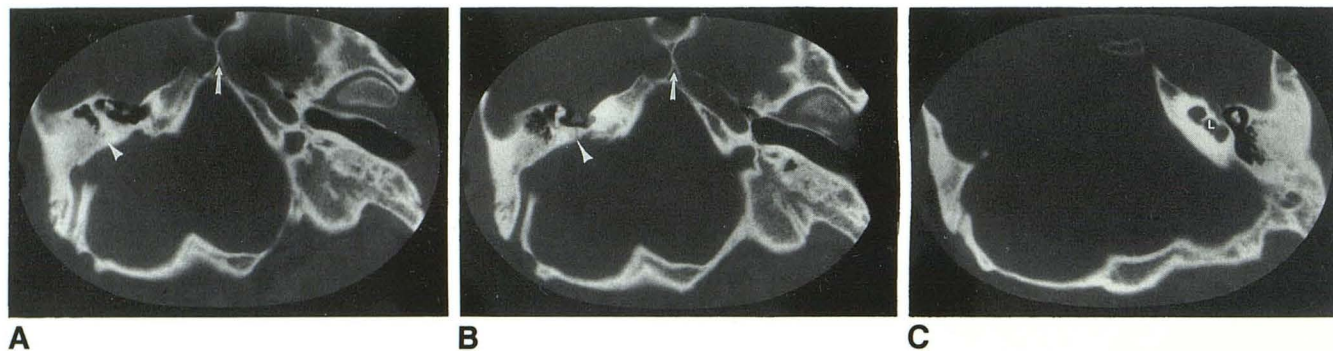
A–C, Serial temporal bone CT from the petrous portion of the internal carotid artery (A) through to the left labyrinth (C). Right temporal bone (A and B); mildly dysplastic middle ear structures. The petrous portion of the temporal bone is nearly absent with aplasia of inner ear structures. Dyplastic facial nerve canal (*arrowhead*). Sphenoid bone (A and B); marked hypoplasia of the body of the sphenoid bone with near apposition of the carotid canals (*arrow*). Left temporal bone (A–C); globular dysplastic bony labyrinth (L).
